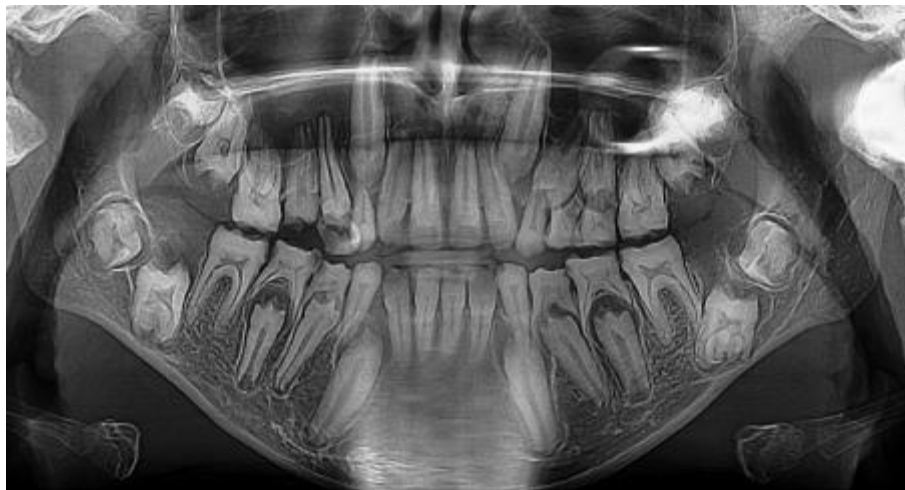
Orthopantomograph showing defective enamel affecting both primary and permanent dentitions
